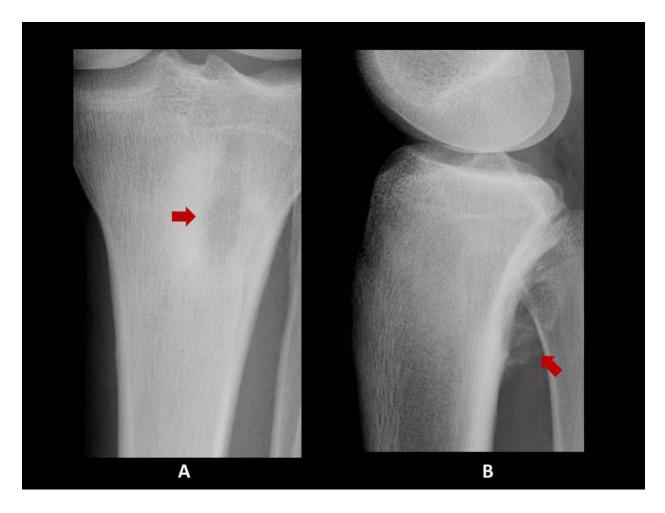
Osteoblastoma. Anterior-posterior (A) and lateral (B) radiographs of the proximal left tibia reveals a geographic lytic lesion in the posterior tibia with cortical expansion and internal matrix mineralization (B, arrow).
